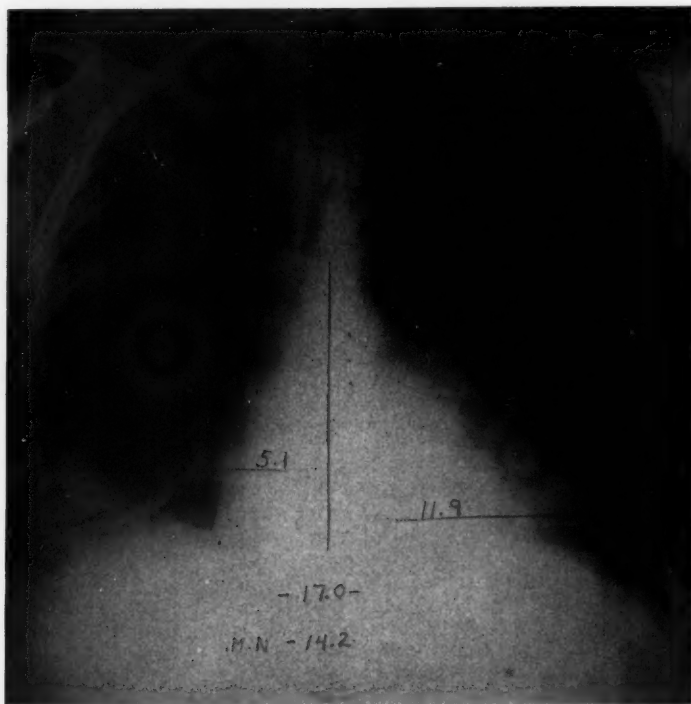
X-ray of the chest dated June 24, 1950, revealing cardiac enlargement with fluid in the right base.
